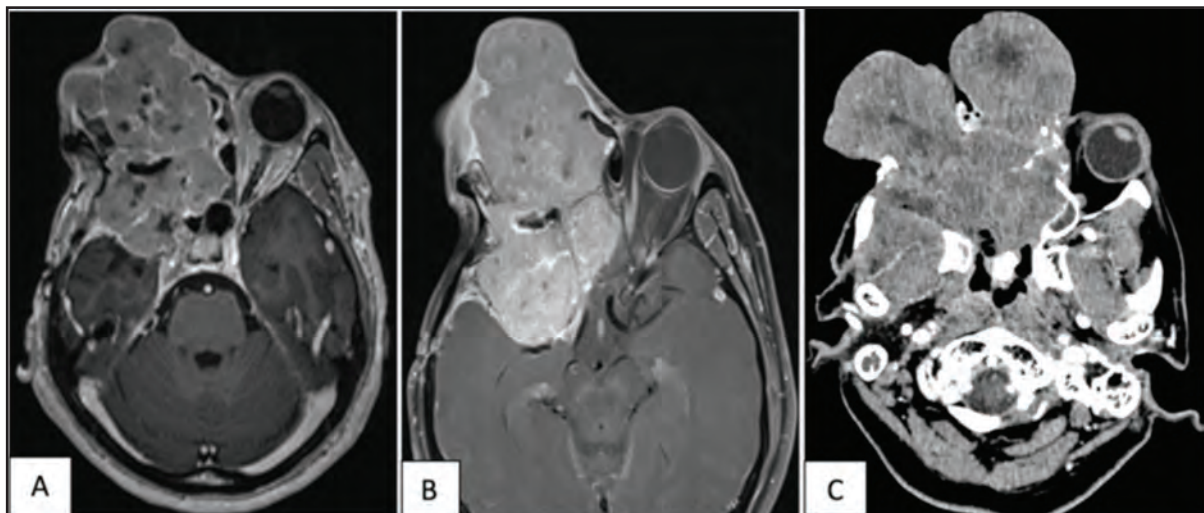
Spheno-orbital meningioma in axial contrast-enhanced T1-weighted MRI reveals (A) marked tumoral growth with lobulated exophytic component at fifth recurrence. The mass extends to the ethmoid and sphenoid sinuses, right cavernous sinus, anterior and medial cranial fossae causing mass effect to the anterior temporal and inferior frontal lobes, (B) marked infiltrative tumour recurrence with heterogenous exophytic component, worsening locoregional and intracranial extension despite of a course of bevacizumab therapy prior the fifth surgery, (C) axial computed tomography (CT) image reveals further progression of infiltrative exophytic tumour recurrence in the right orbit, nasal cavity and paranasal sinuses with increasing degree of intracranial extension to bilateral anterior and right middle cranial fossae at sixth recurrence
